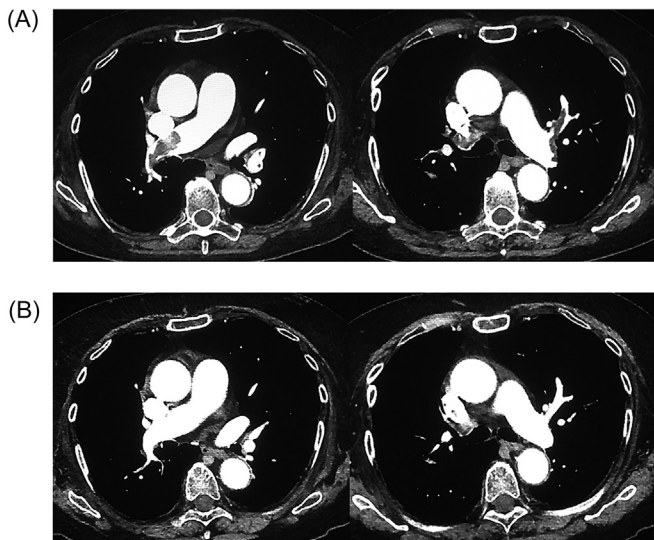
Contrast computed tomography (CT) scan of the pulmonary arteries. A thrombus is shown in both pulmonary arteries (A). A contrast CT scan 2 months from starting anticoagulant treatment showing no evidence of a thrombus (B).
